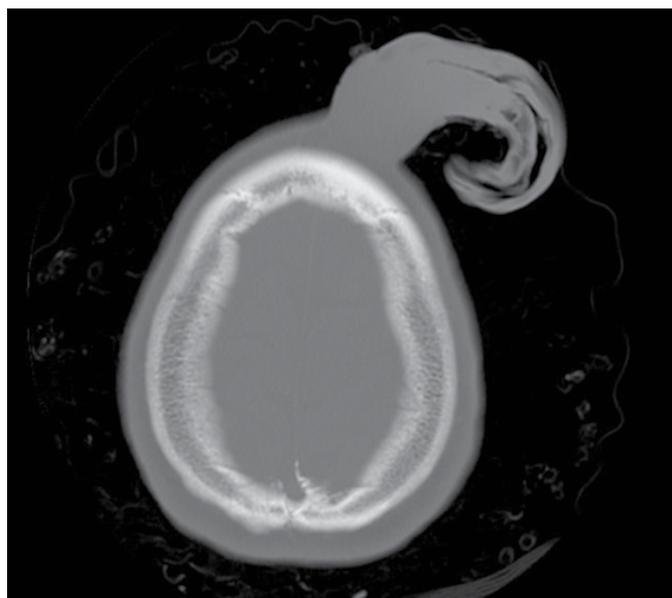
Lesion on computed tomography scan. No bony attachment was seen.
